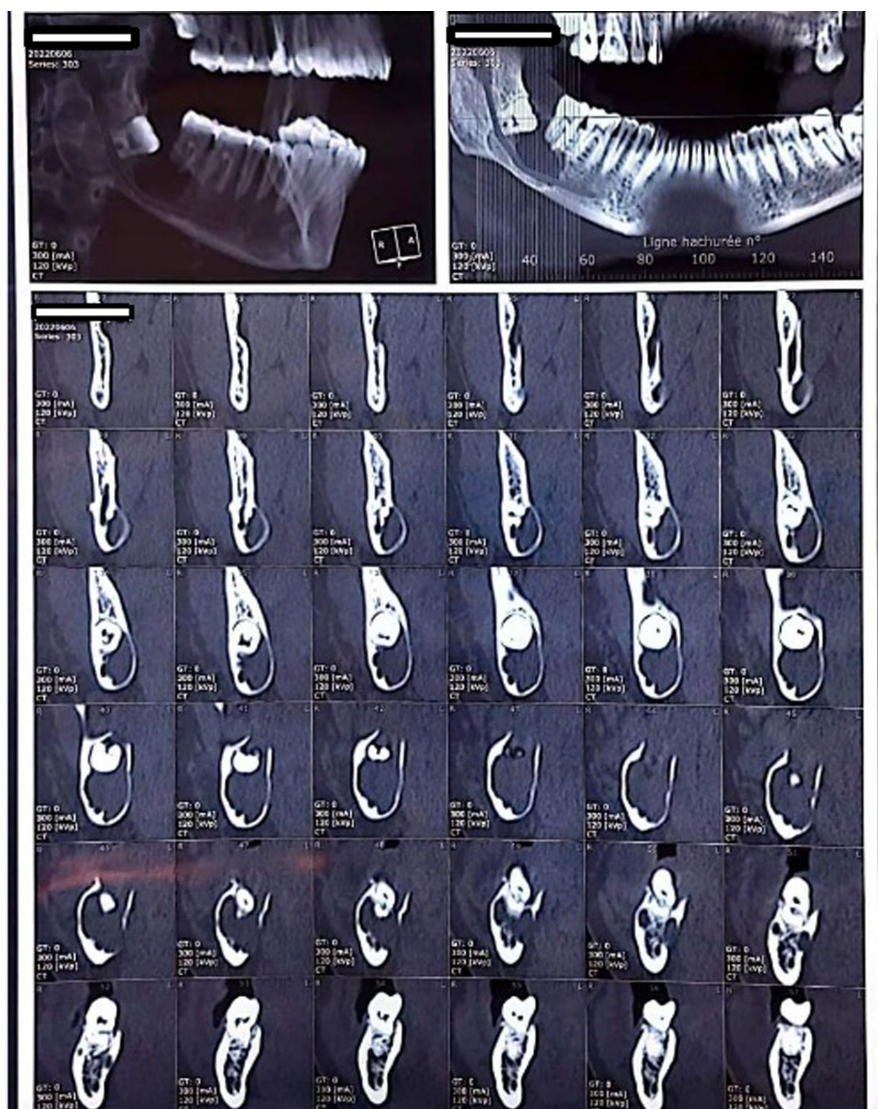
Cone-beam computed tomography shows a well-defined hypodense image on the right mandibular angle + impacted third molar.
